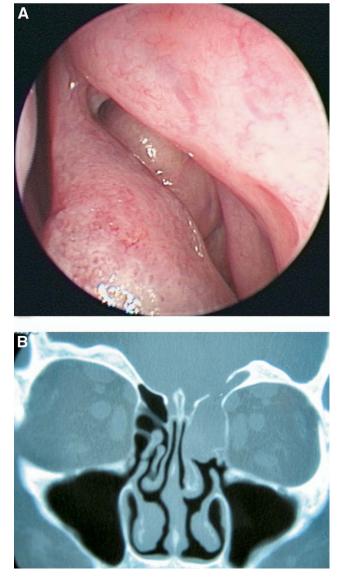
(A) Transnasal endoscopic view of a left supraorbital ethmoid encephalocele. Clinically, intracranial pressure is transmitted to the encephalocele sac, resulting in pulsations. (B) The encephalocele originated from a skull base defect in the roof of the left supraorbital ethmoid sinus, as demonstrated by coronal CT scan.
